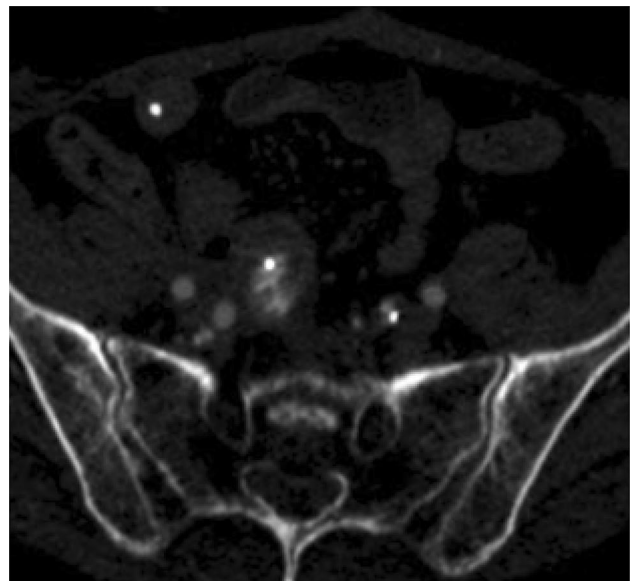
Intra-ureteral contrast medium in areterial phase of CT-Scan
